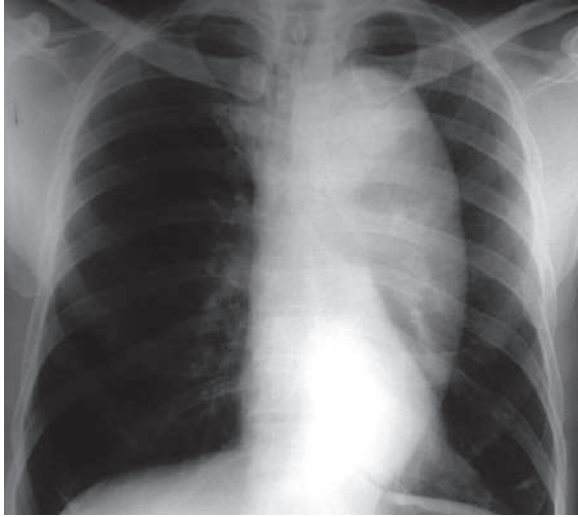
Posteroanterior chest radiograph of a patient with thoracic aortic aneurysm (TAA) shows marked dilatation of the aortic knuckle and the descending thoracic aorta
